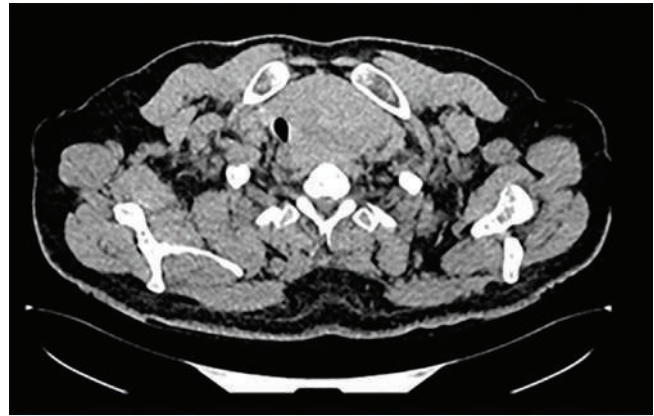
Computed tomography (CT) image demonstrating an approximately 10 cm mass in the left thyroid lobe.
